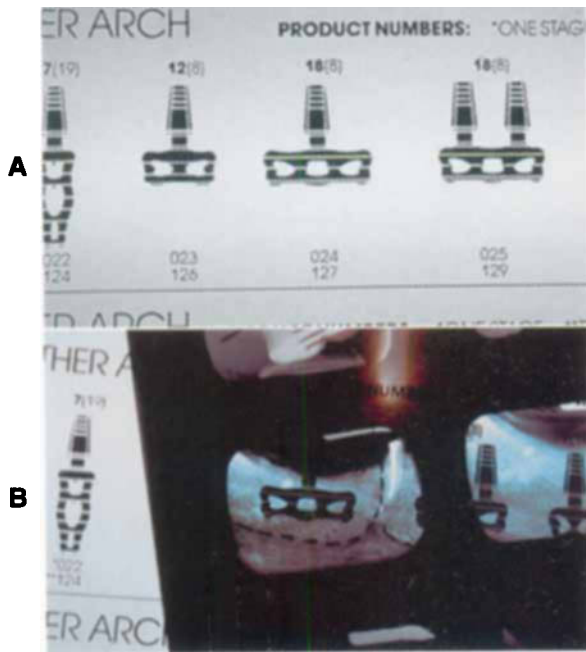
■ Implant overlay (A) placed over periapical radiograph indicates adequate clearance around implant (B).
